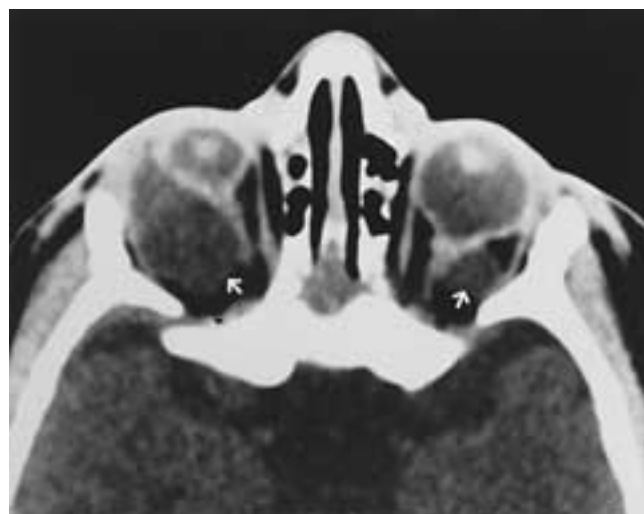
Colobomatous cyst. Axial CT scan shows microphthalmic eyes with large cysts (*arrows*).
